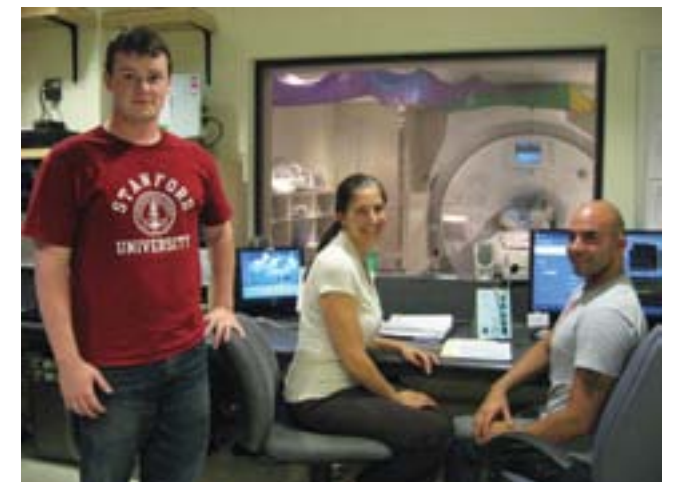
Researchers from the Department of Neurology (Principal Investigator Kathleen Poston, MD) conduct a functional MRI scan at 3T2 on a patient enrolled in a study of Parkinson's Disease.
